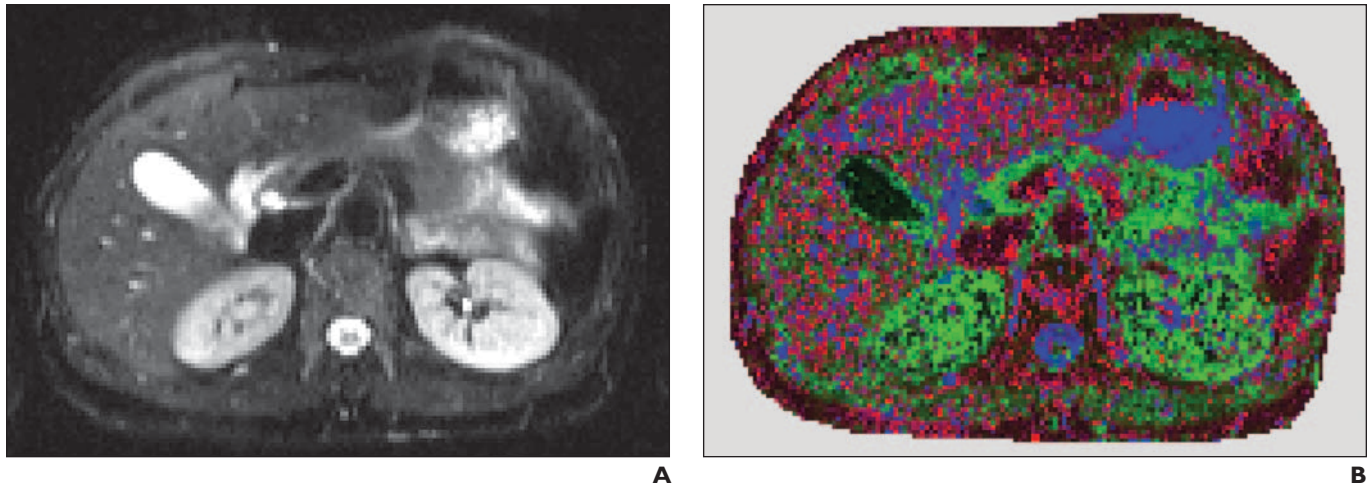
25-year-old healthy woman who underwent axial diffusion-weighted (DW) MRI using navigator-controlled spin-echo echo-planar imaging with 10 b values (0, 25, 50, 75, 100, 150, 250, 500, 750, and 900 s/mm²).
